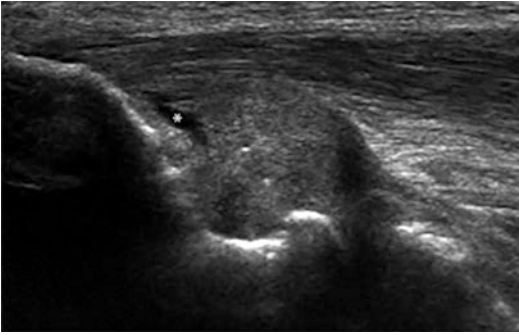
Longitudinal ultrasound view of the thickened anterior band of the ulnar collateral ligament with a focal tear (*)
